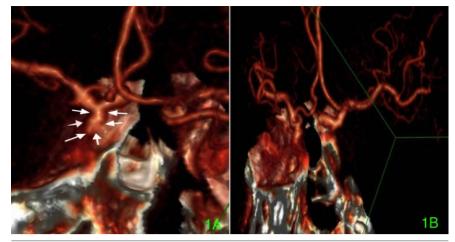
A-B) Computed tomography angiography images showing an aneurysm in between the C4 segment of the left internal carotid artery and the bifurcation of the left posterior communicating artery. White arrows = aneurysm.
